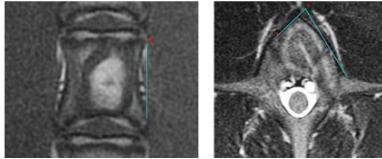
MRI performed two weeks after procedure demonstrated bone marrow signal consistent with controlled damage.
